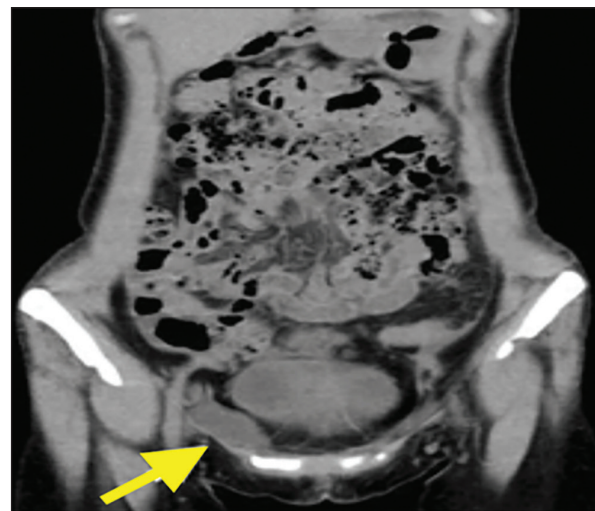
Coronal contrast enhanced abdominal CT scan. A well-circumscribed mass measuring 4,5x2cm (yellow arrow).
